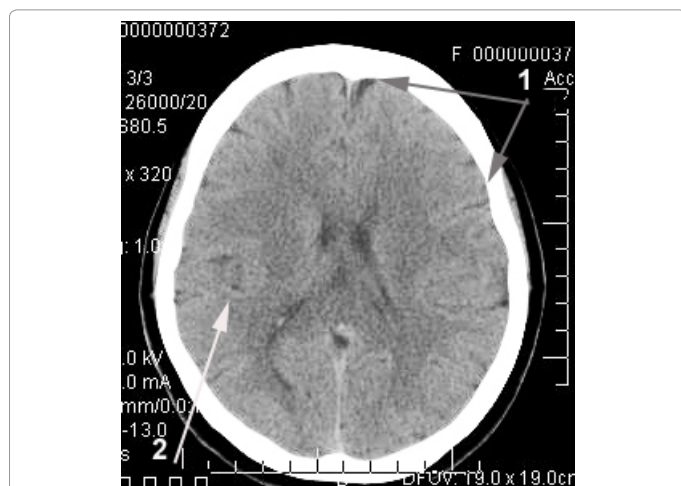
Patient H.: Female, 60 years old: CT of the brain. Before the Intervention: 1) moderate expansion of the subarachnoid space; 2) moderate heterogeneous post-ischemic cyst in the right middle cerebral artery region.
